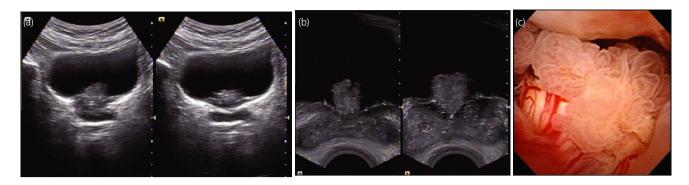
Preoperative examination. (a) Transabdominal ultrasonography of the villous adenoma. The origin of mass is not clearly visible on the ultrasonogram. (b) Transrectal ultrasonography of the villous adenoma. The ultrasonogram shows the mass which seems to have risen from the bladder neck or intravesical protruding prostate. (c) Cystoscopic examination shows multiple papillary lesions sized approximately 2 cm surrounding the bladder neck.
